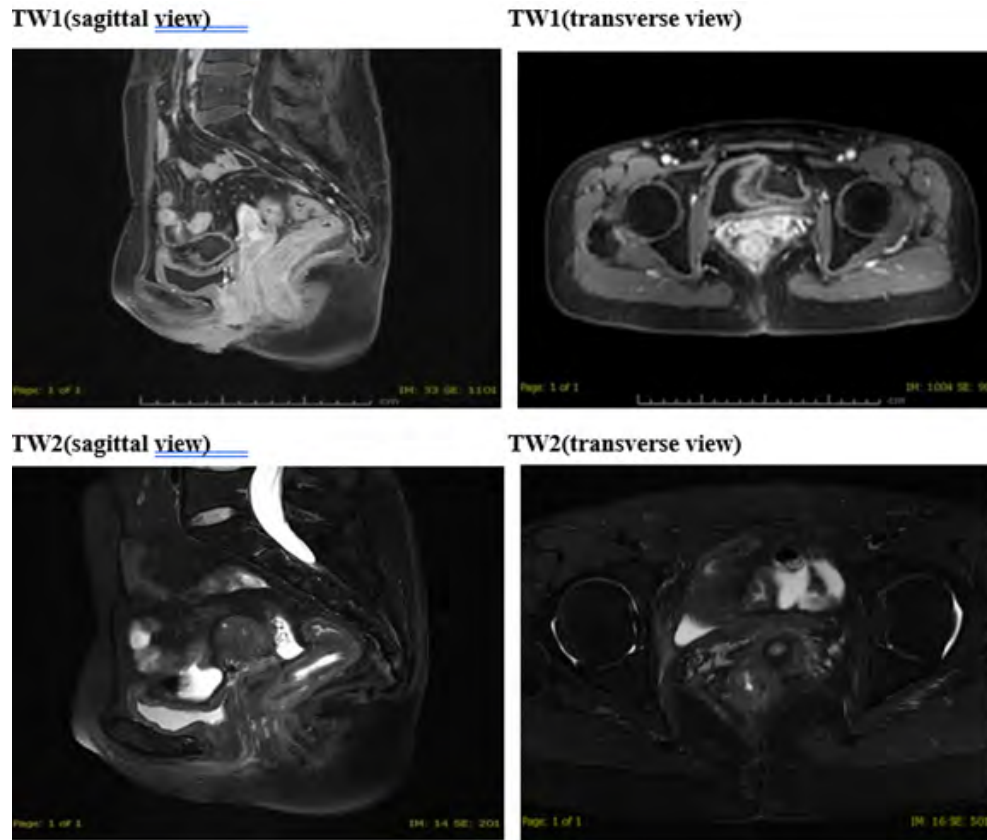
Enhanced MRI follow-up. The intestinal wall of the lower rectum is slightly thickened, with an upper and lower range of 31 mm, homogeneous enhancement, and the boundary with the surrounding organs is clear, which is considered to be rectal intestinal wall edema after chemoradiotherapy. No obvious diffusion-restricted nodules noticed in the rectum, sacrum and bilateral iliac bones.
